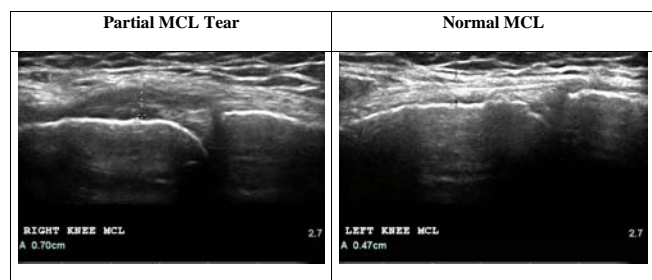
Ultrasound of partial MCL tear and normal MCL.
